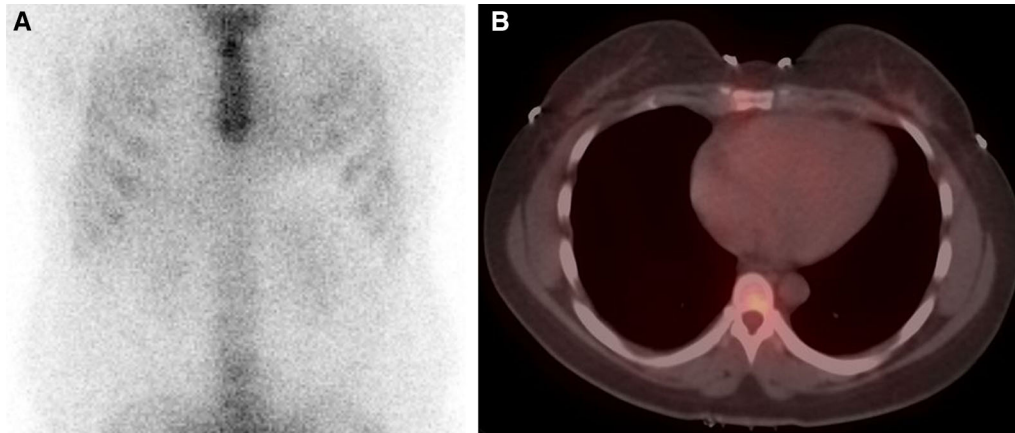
Negative ^{99m}Tc -PYP scan (Planar and axial SPECT/CT) with no appreciable myocardial tracer uptake (Perugini Score Grade 0).
